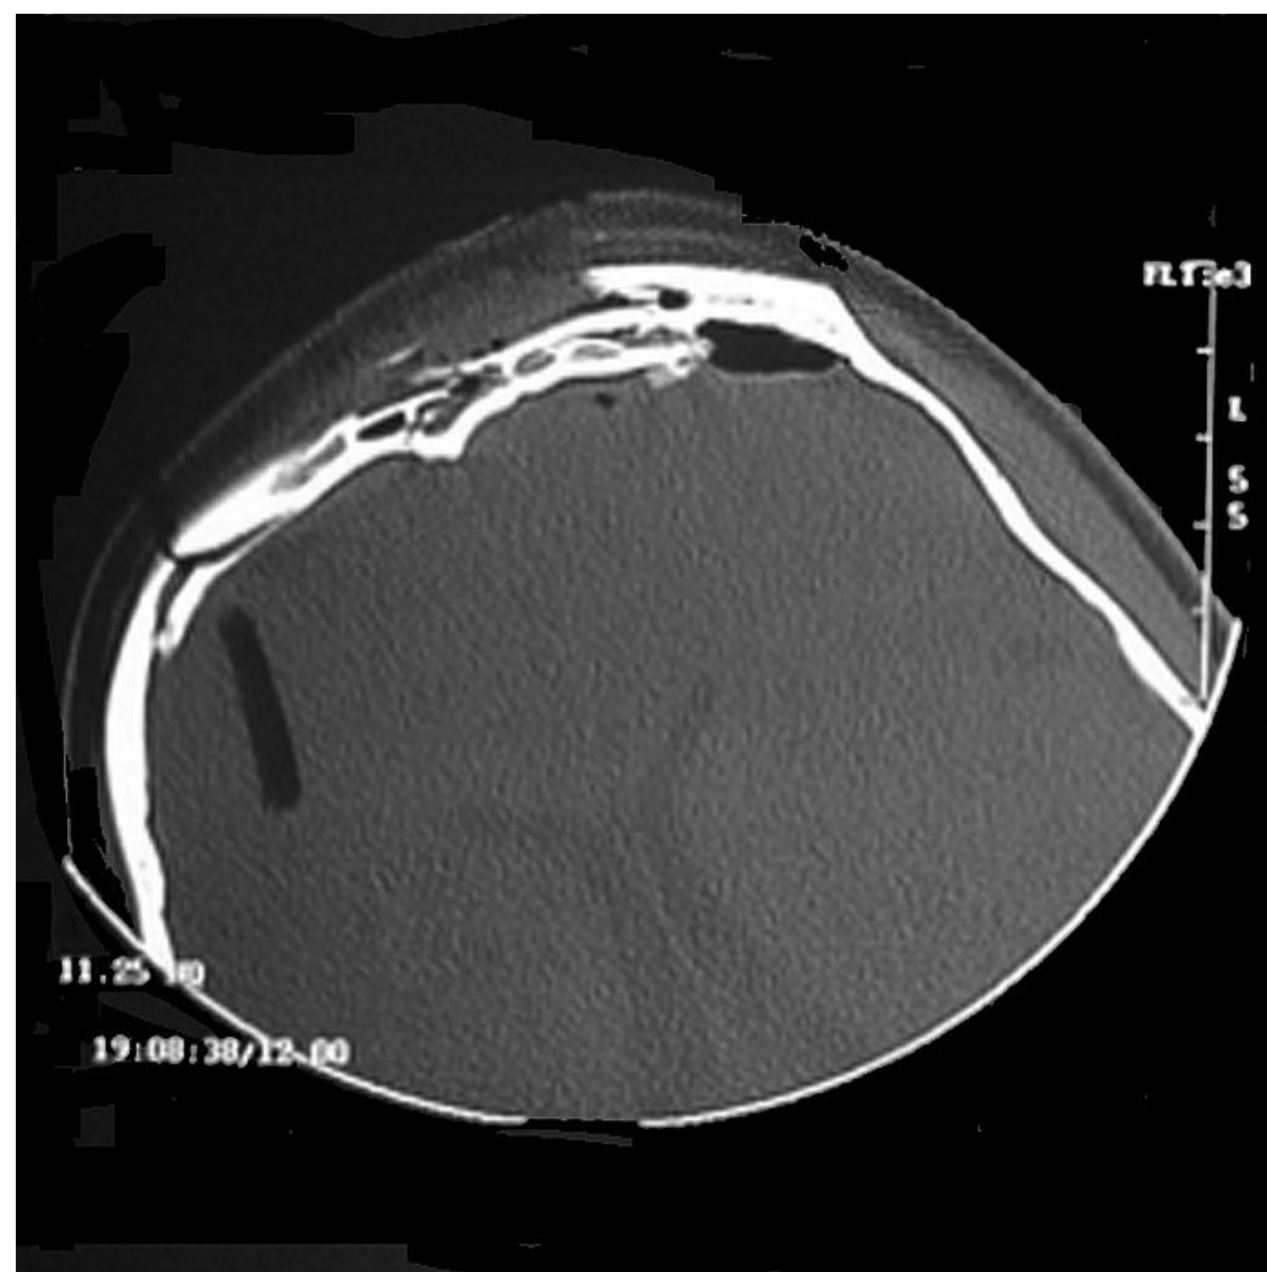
CT demonstrating a fracture involving both the anterior and posterior tables of the frontal sinus.
